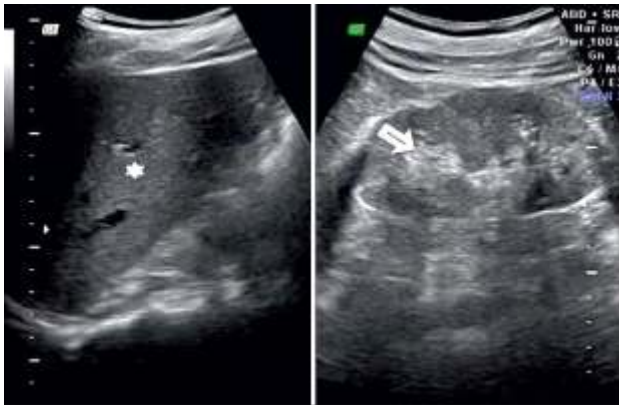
The longitudinal segment of the abdominal ultrasound reveals Grade 2 renal cortical echogenicity, meaning the left kidney's cortico-medullary definition (arrow) is preserved whereas the liver's echogenicity is less.
